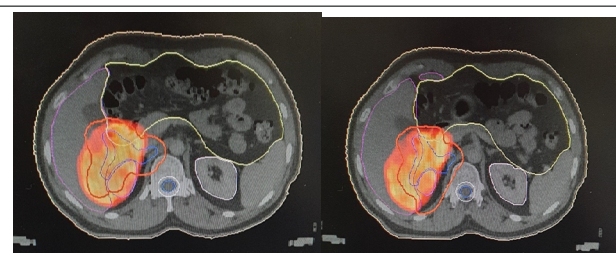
Planning CT scan fused with initial PETCT scan showing contour coverage of the initial disease.
